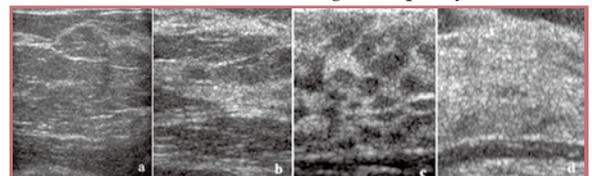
sonography of different breast compositions
